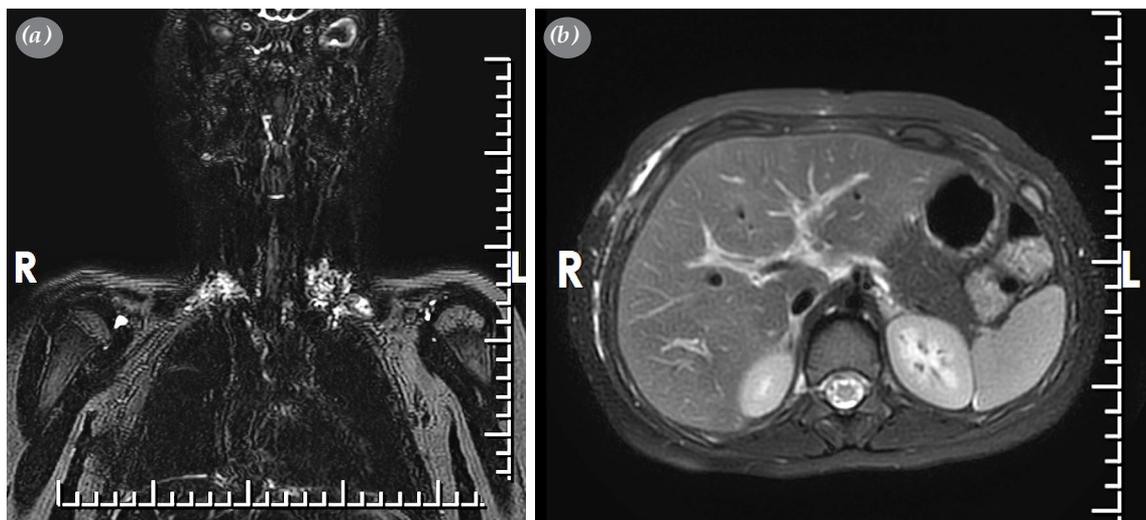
(a) T2-weighted magnetic resonance imaging results obtained after the fenestration dilatation process revealed that the lymphatic changes had disappeared. (b) The signal changes in the pleura and retroaortic region had significantly regressed.
